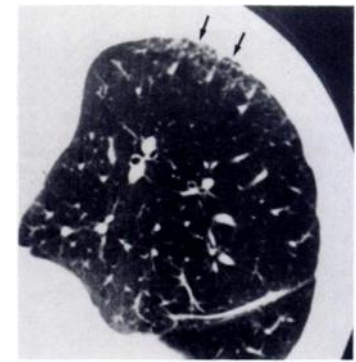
High-resolution CT scan with subject prone shows focal subpleural honeycombing and interlobular septal thickening at right base (arrows).
